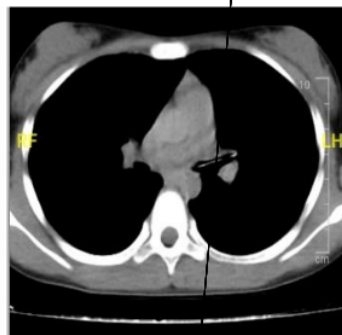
Chest CT Scan with contrast in axial view
